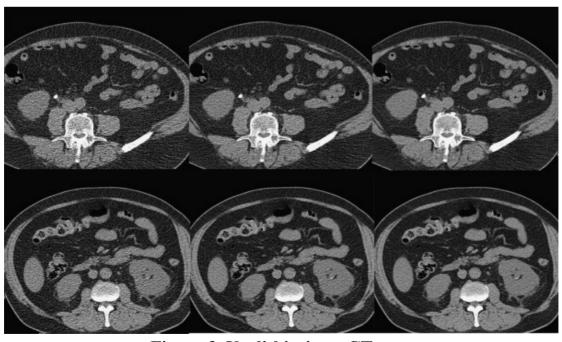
Urolithiasis on CT scan
